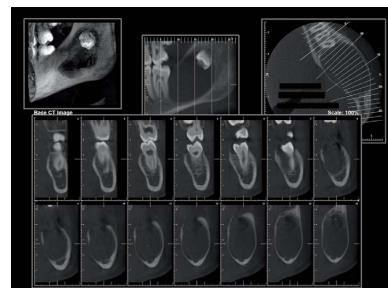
Computed tomography showing the presence of cortical bone expansion.
